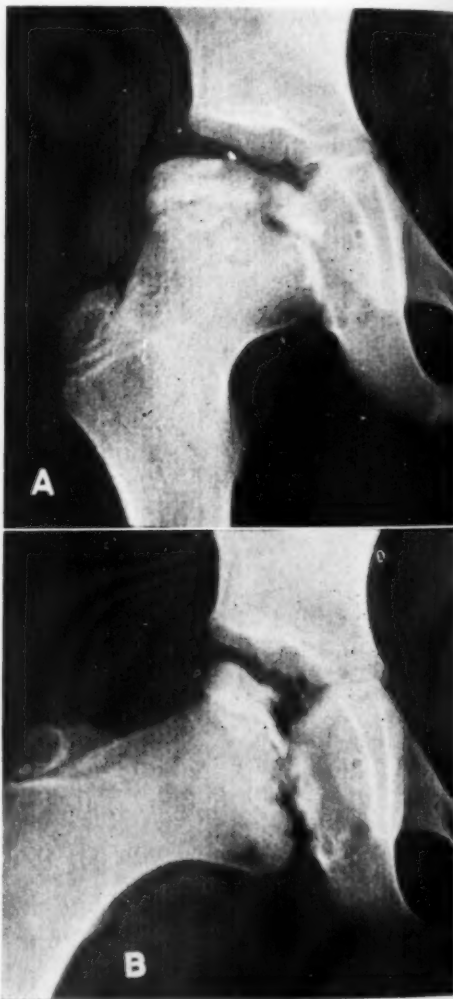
Roentgenograms of the hip of a patient with Perthes' disease: mottling and irregularity of the head seen on the anteroposterior view (A), with a definite defect seen clearly only on internal rotation (B).
